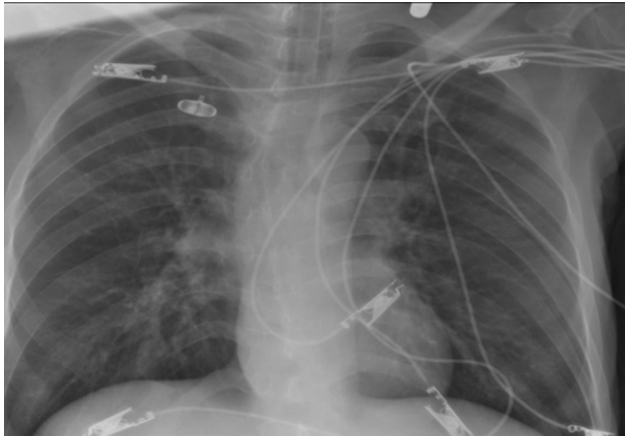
Normal chest X-ray on day 1 of admission.
